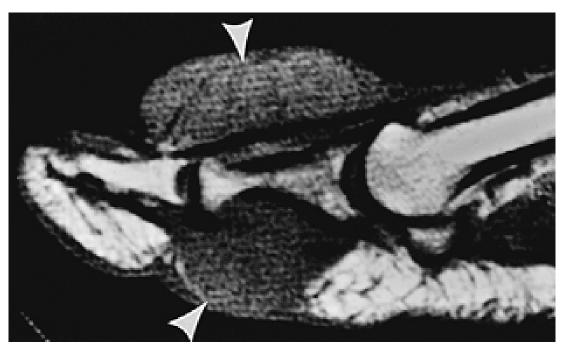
Synovial sarcoma; T1W sagittal image of the great toe. A large, intermediate signal mass (*arrowheads*) surrounds the great toe. This is a nonspecific MRI appearance, but was found to be a synovial sarcoma at surgery.
